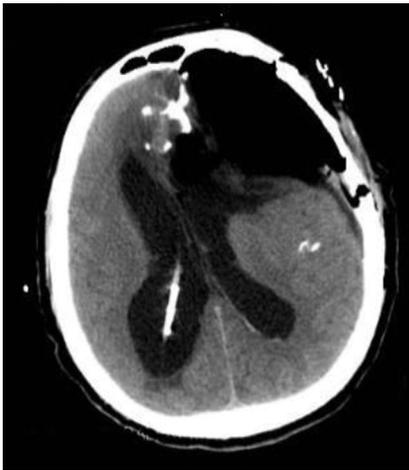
Postoperative brain computed tomography scan.
